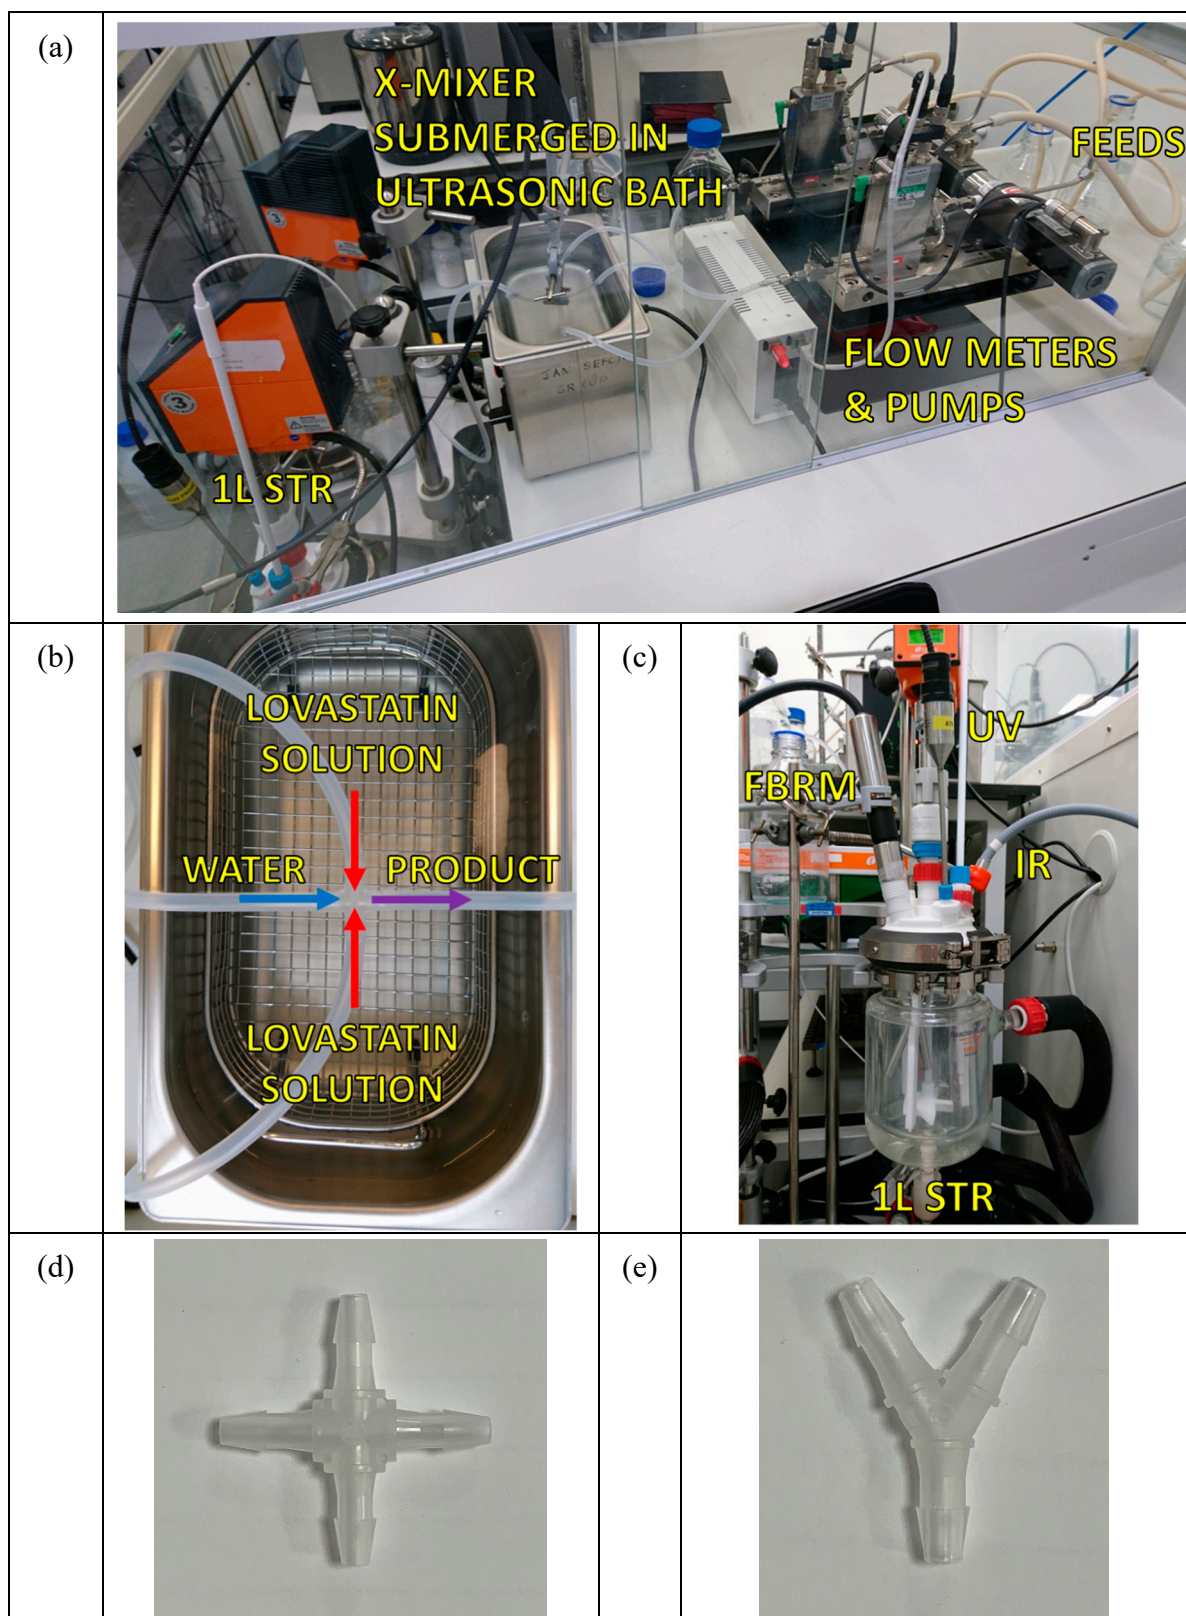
Photographs of (a) the full antisolvent crystallisation experimental setup (not running), (b) the X-mixer connected to the tubing in the ultrasonic bath, (c) a close-up view of the 1 L jacketed STR with the PAT probes inserted, (d) a close-up, top-down view of only the X-mixer, and (e) a close-up, top-down view of only the Y-splitter.
